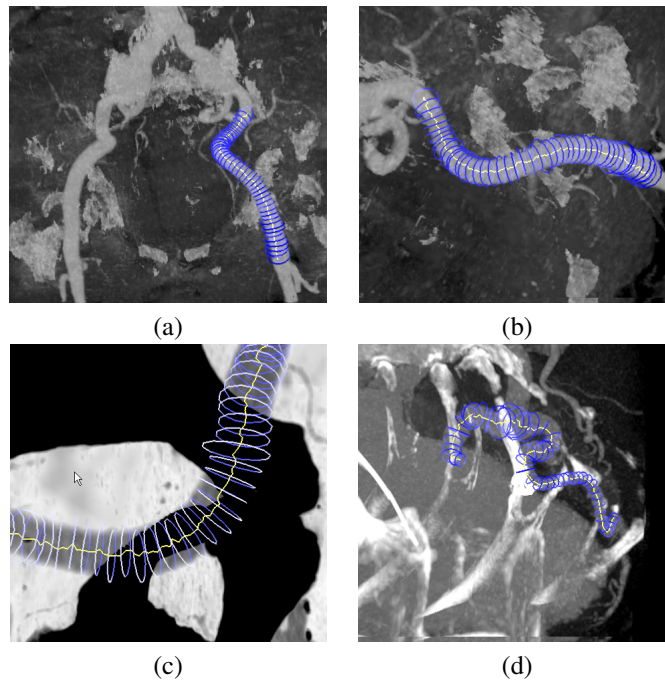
Qualitative experiments on real CTA datasets. (a)(b)(c) Iliac arteries. (d) Major heart vessel.
